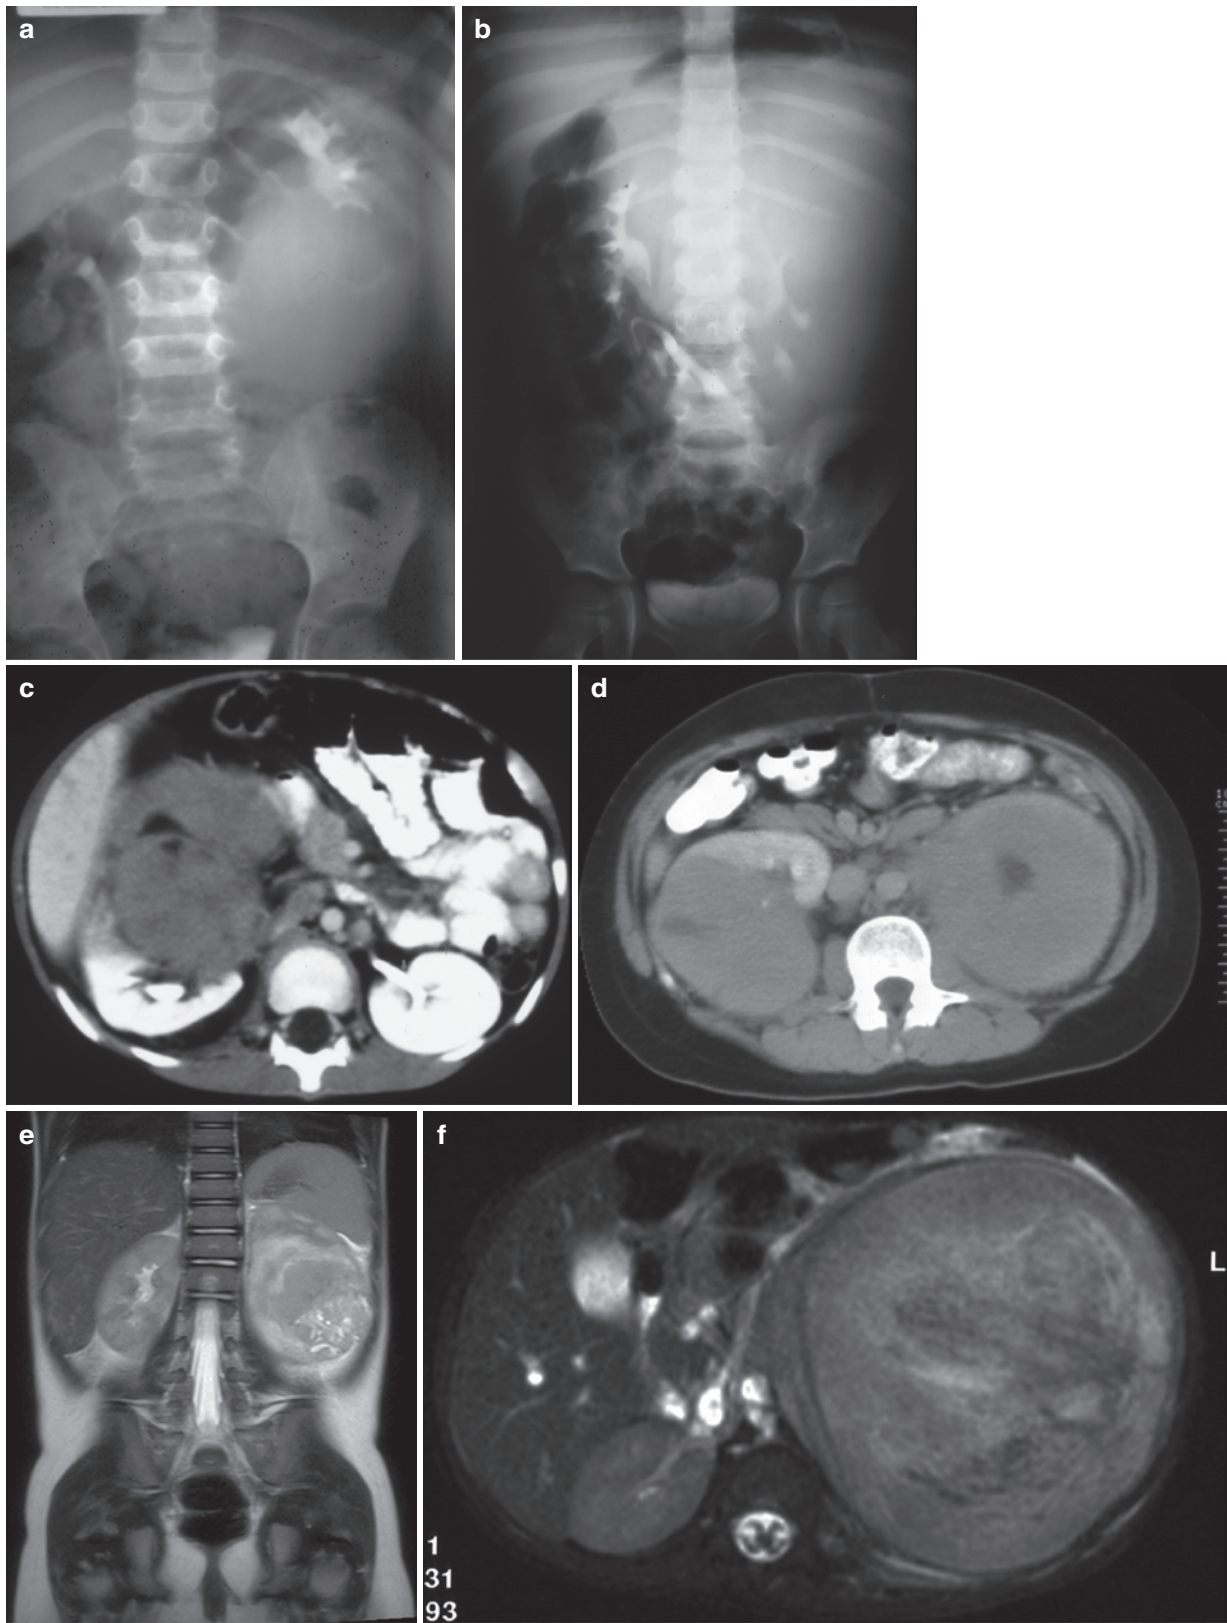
(a) Intravenous urogram showing a nephroblastoma (Wilms') arising from the upper pole of left kidney. (b) Intravenous urogram showing deformity of the pelvicalyceal system. A large nephroblastoma arising from the left kidney crossing the midline. (c) CT scan showing nephroblastoma in cross section with extrarenal
